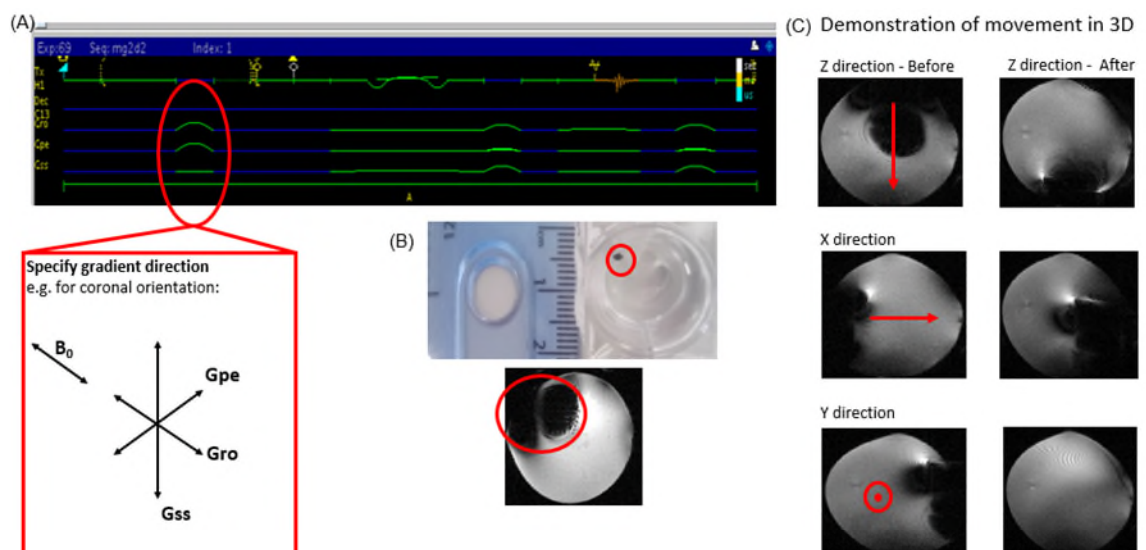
Demonstration of 3D movement of millimeter-sized iron-oxide seeds using MRI gradients. (A) Magnetic targeting pulse sequence on MRI software. Three dimensional gradient directions (G_{pe} , G_{ro} , G_{ss}) can be controlled for any image orientation. (B) Iron-oxide particle in a water sample and the gradient echo image of the particle. (C) Movement of the iron-oxide particle in three-dimensions using MRI. Location of the particle and the direction of applied force indicated on pre magnetic targeting images and the position of the particle on the same slice visible on the post image.
